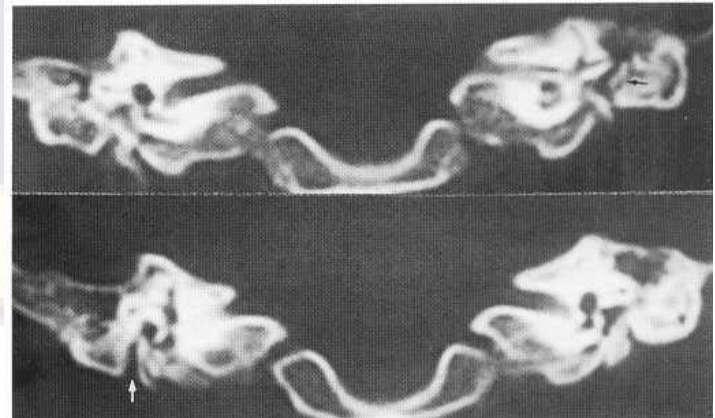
Bilateral metal atresia shown by two coronal CT sections. There are small middle ear cavities, and some hypoplastic ossicles can be identified (black arrow). The tegmen is depressed unilaterally and the descending facial canal (white arrow) is at the level of the oval window.
